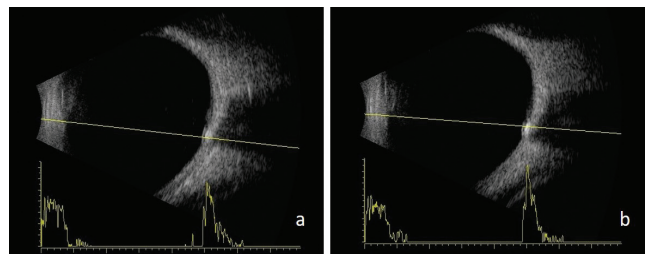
Hyperechogenic appearance on the papilla on ultrasonography in the right (a) and left (b) eyes
